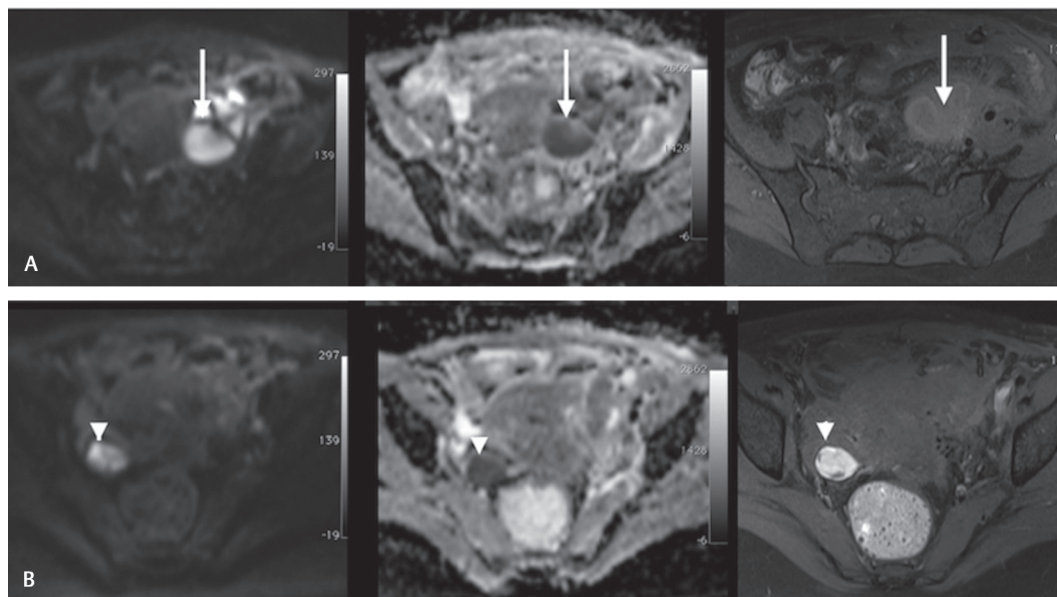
(A, B) (A, top row): DWI, ADC, and FS T1W images in the axial plane showing an abscess with restricted diffusion and peripheral T1W hyperintensity (*arrow*). (B, bottom row): DWI, ADC, and FS T1W images in the axial plane showing an endometrioma with restricted diffusion and T1W hyperintensity (*arrowhead*). ADC, apparent diffusion coefficient; DWI, diffusion-weighted image; FS, fat-suppressed; T1W, T1-weighted.
